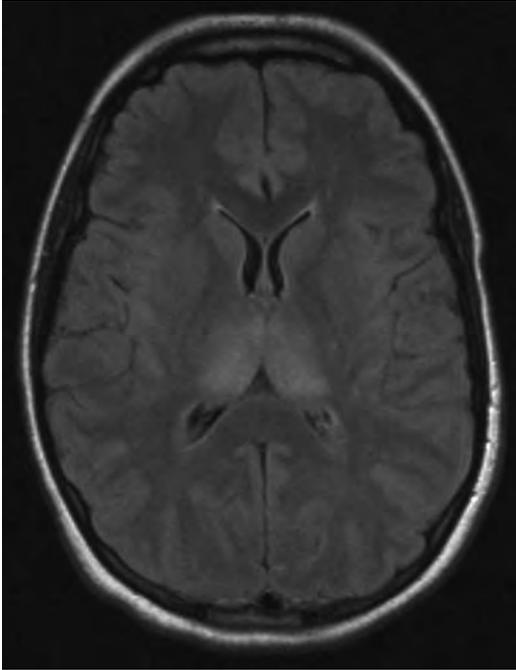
FLAIR MRI from a 19-year-old woman who presented with an altered level of consciousness and status epilepticus. There is intensely increased T2 signal in the thalamus bilaterally. CSF demonstrated a WBC count of 17 (predominantly lymphocytes) and a protein concentration of 0.80 g/L. PCR testing was positive for enteroviral DNA. More subtle T2 signal change was observed in the temporal and occipital horns bilaterally. She improved rapidly during her hospitalization and was discharged home. Follow-up MRI revealed complete resolution of the MRI findings.
